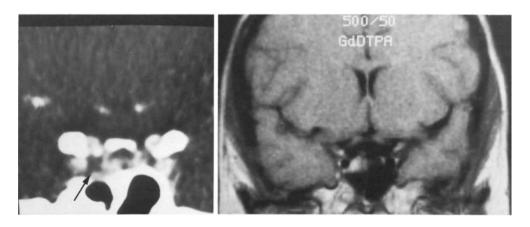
Coronal CT after administration of contrast medium (left) and MRT with TR/TE of 500 ms/50 ms after Gd-DTPA administration (right) in a 27-year-old female patient with hyperprolactinemia (276 ng/ml). Several intrasellar hypodense lesions on CT make it difficult to localize the microadenoma unequivocally (arrow). On MRT, unequivocal localization of the microadenoma as the hyperintense structure on the right
